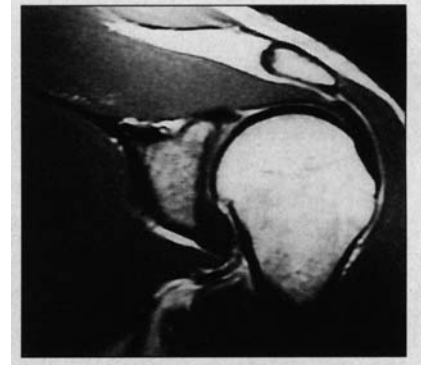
Magnetic resonance image of the shoulder showing rotator cuff tendonitis.
